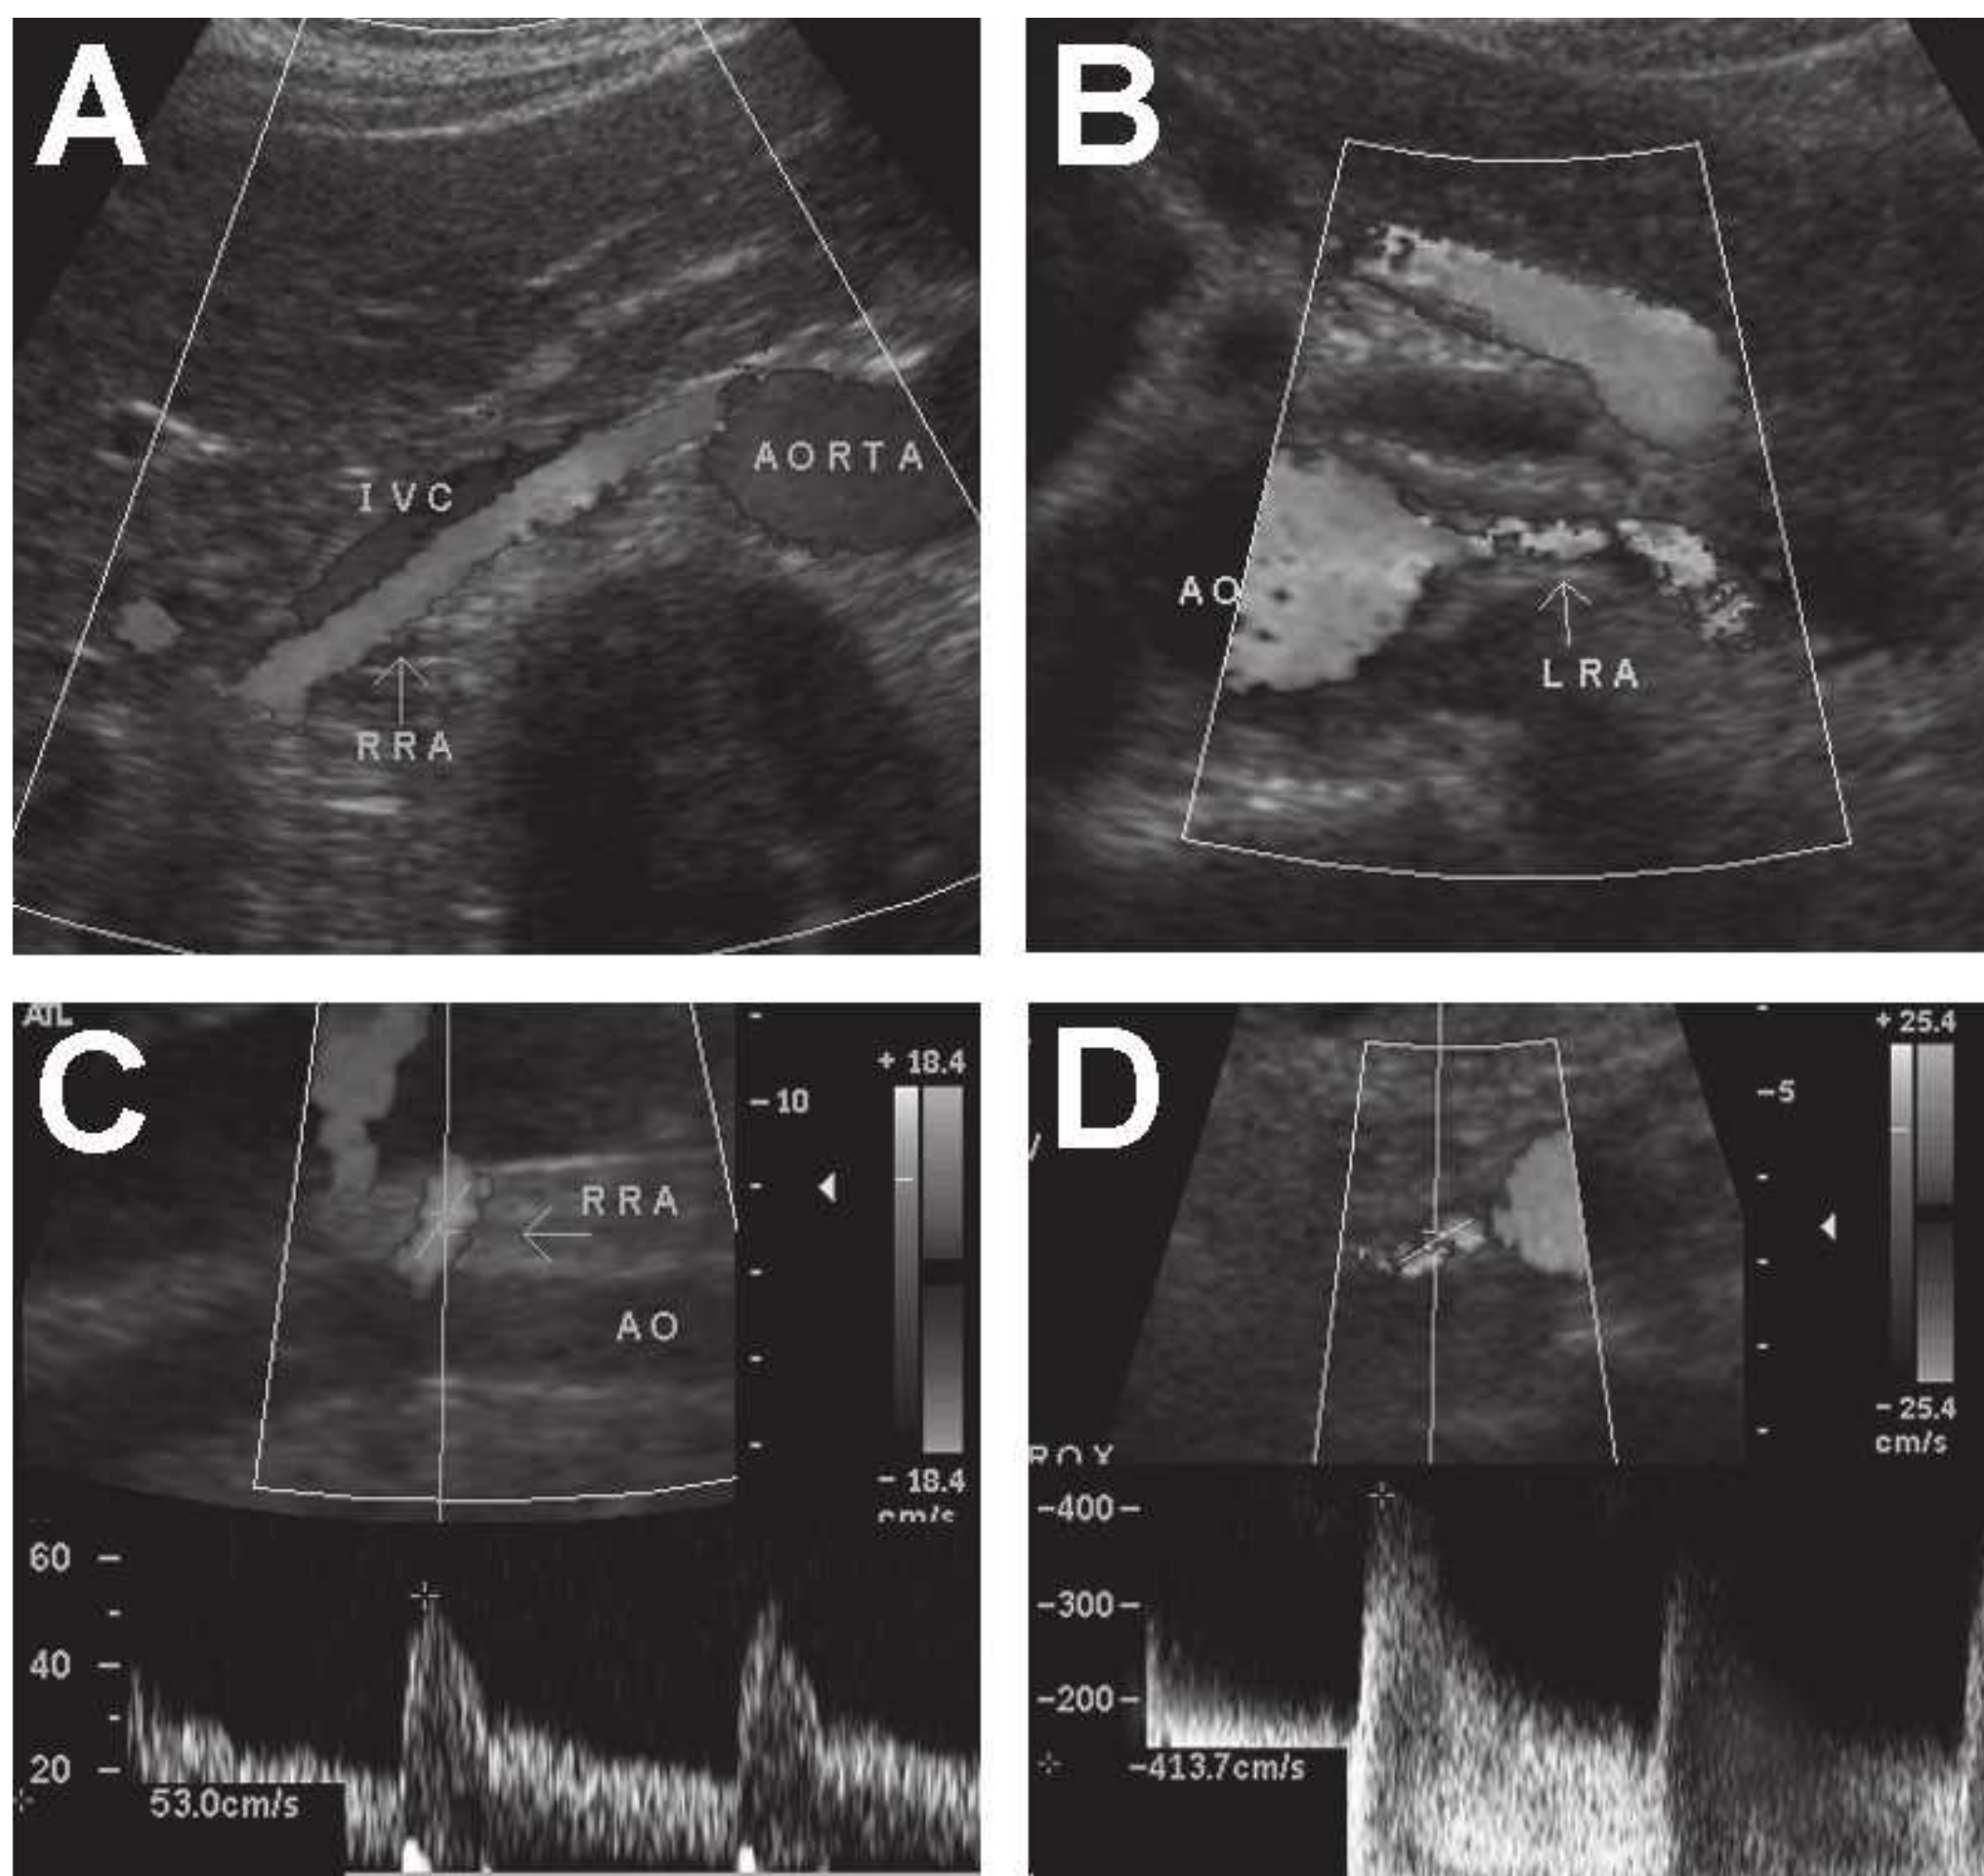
Renal artery Doppler. A: Normal right renal artery, midline transverse image. B: Stenotic left renal artery, midline transverse image. Note the turbulent flow (speckled color pattern) and the poststenotic dilatation. C: Normal right renal artery, coronal view, with a peak systolic velocity of 53 m per second. D: Stenotic right renal artery, midline transverse view. The peak systolic velocity averages well over 300 m per second. (Images courtesy of Sue Zellman, RDMS, RVT.)
